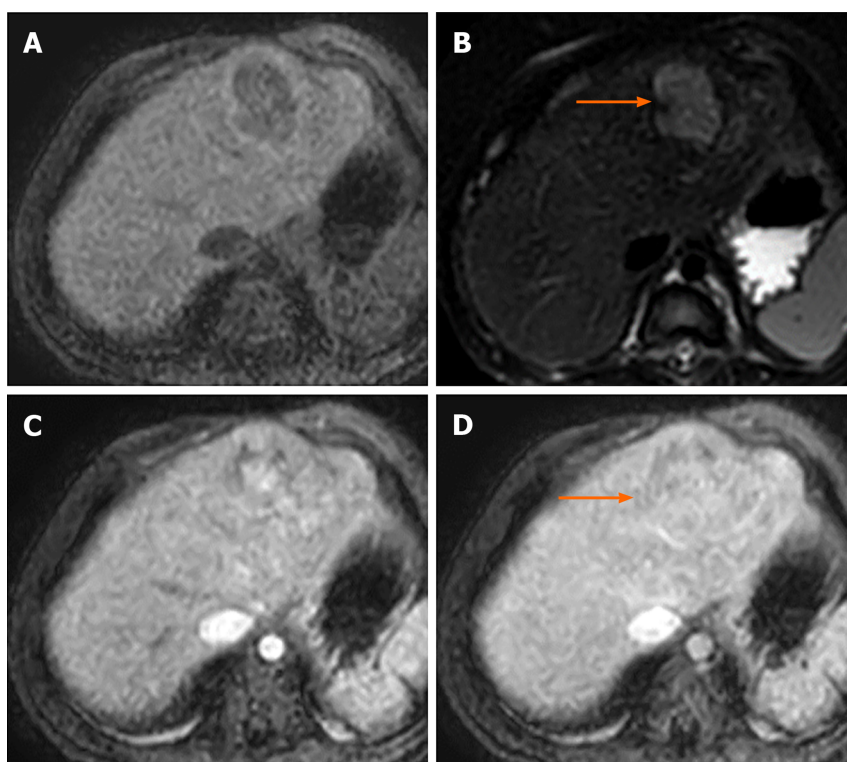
Magnetic resonance images of a 2-year-old boy with underlying abernethy malformation presenting with an incidentally identified liver mass with pathological tissue diagnosed hepatoblastoma. A: Mass showing well-defined hypointense liver parenchyma on T1W and; B: Hyperintense parenchyma on T2W images; C: This mass revealed heterogeneous arterial hyperenhancement; and D: Venous enhancement after the administration of gadolinium-based contrast agent.
